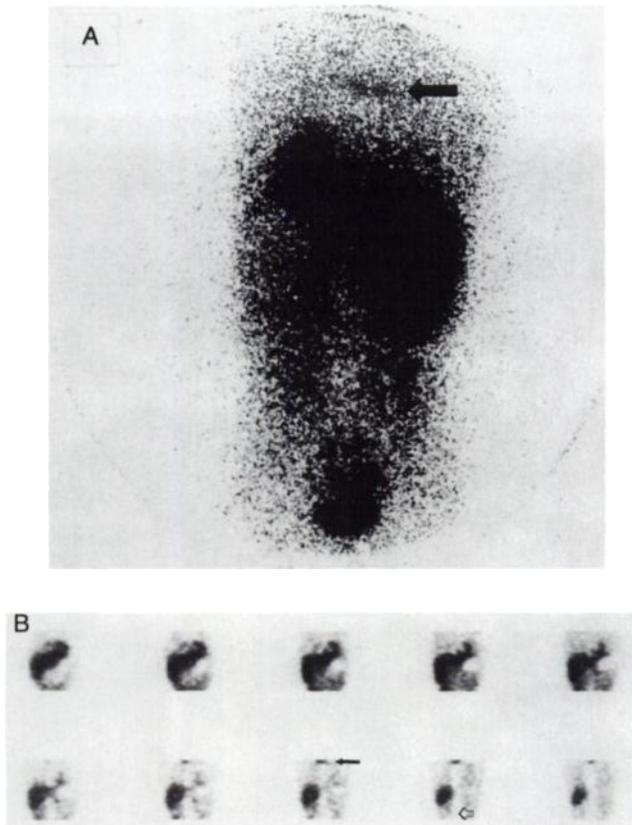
This 3-yr-old girl with treated neuroblastoma was being evaluated for BMT. Uptake in the thoracic spine (closed arrows), seen on planar (A) and coronal SPECT (B) imaging, is consistent with an unsuspected metastasis. SPECT precisely localizes the abnormal uptake to the spine. Uptake in unaffected spine is less than soft-tissue background activity (open arrow).
